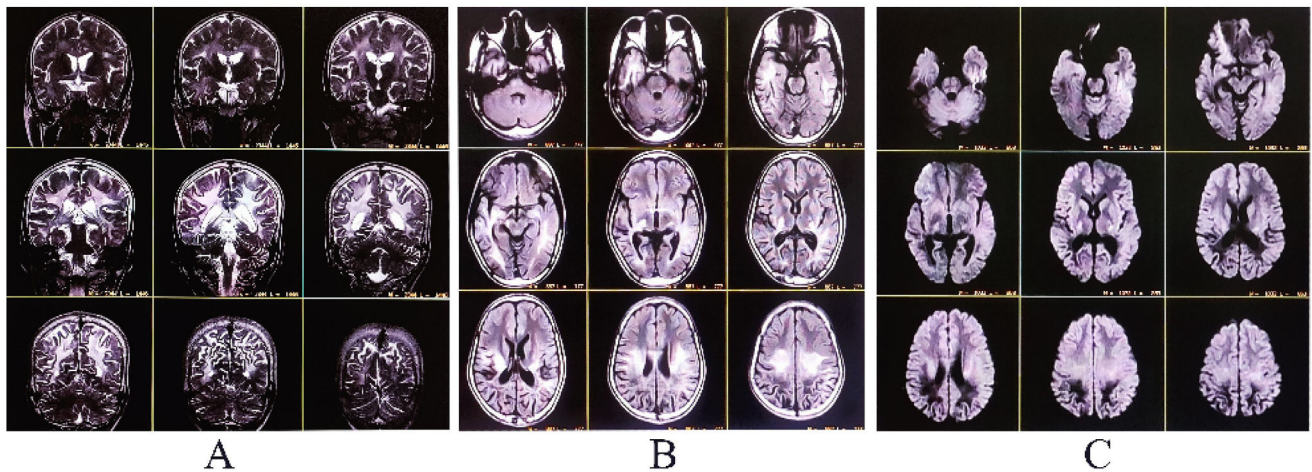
MRI of the brain revealed non-enhancing altered intensity lesions hyper on coronal-T2-WI (A), axial-T2-WI (B), and axial-DWI (C) involving bilateral temporal-parietal-occipital region, posterior limb of the internal capsule, thalamus, and splenium of the corpus callosum with adjacent dilated sulci and dilated occipital horns of both lateral ventricles suggestive of posterior-predominant leukodystrophy.
